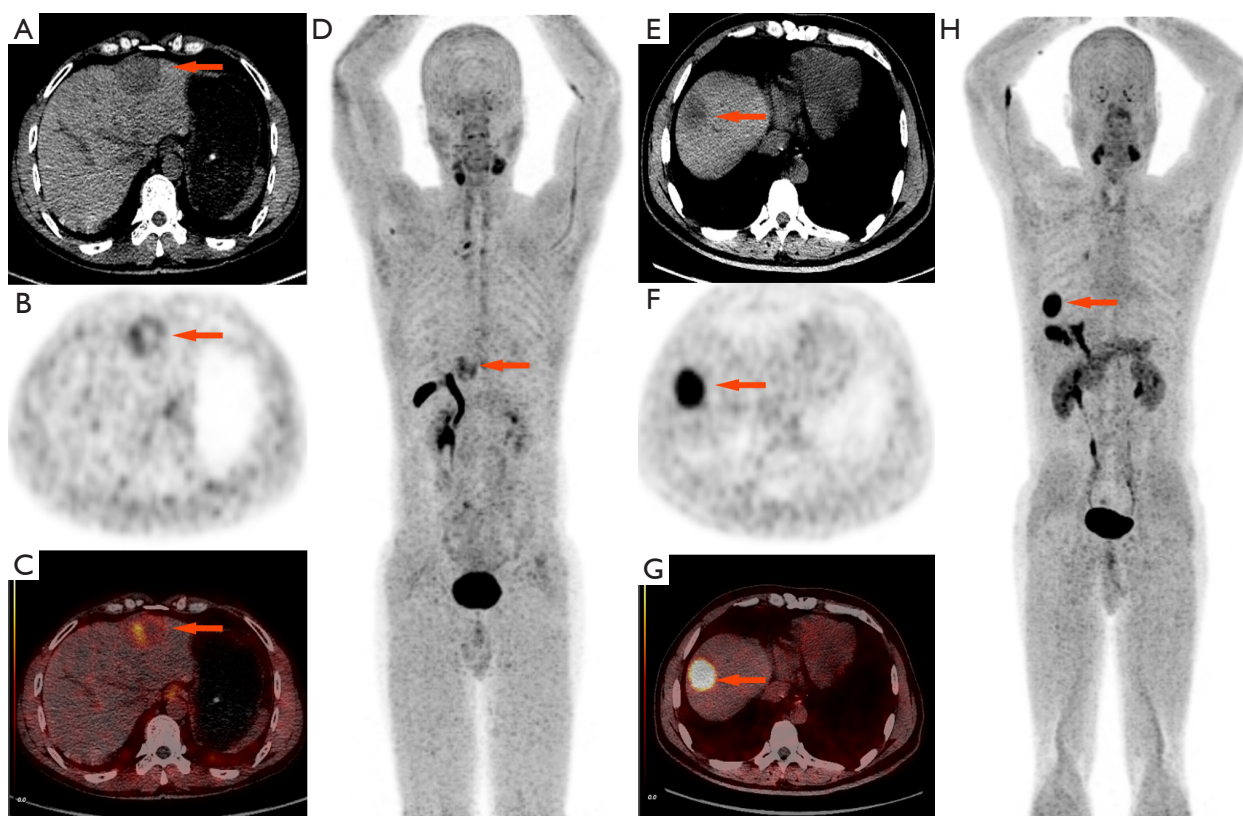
Representative images for both HCC and ICC. (A) Transaxial CT, (B) transaxial PET, (C) transaxial fusion PET/CT, and (D) MIP (anterior view) in a 48-year-old man patient with HCC; the mass was in his hepatic II segment (arrow), its size was about 4.0 cm × 3.8 cm, and the SUVmax was 4.1. (E) Transaxial CT, (F) transaxial PET, (G) transaxial fusion PET/CT, and (H) MIP (anterior view) in a 50-year-old man with ICC. The mass (arrow) was about 3.5 cm × 3.2 cm, with significantly increased FAPI uptake (SUVmax =14.9). HCC, hepatocellular carcinoma; ICC, intrahepatic cholangiocarcinoma; CT, computed tomography; PET, positron emission tomography; MIP, maximum intensity projection; SUVmax, maximum standardized uptake value; FAPI, fibroblast activation protein inhibitor.
